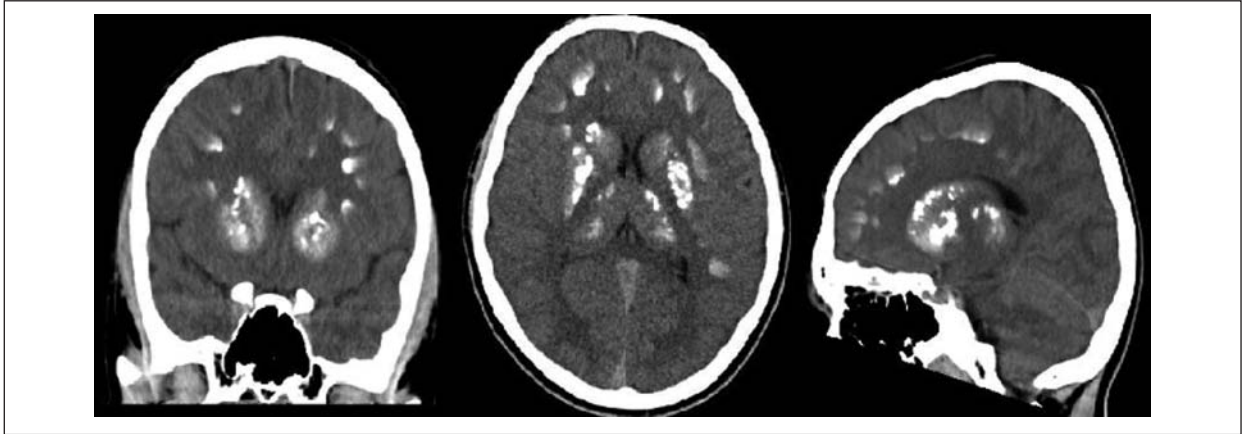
Different views of the computed tomography scan of the head showing extensive cerebral calcifications in a patient with hypoparathyroidism
